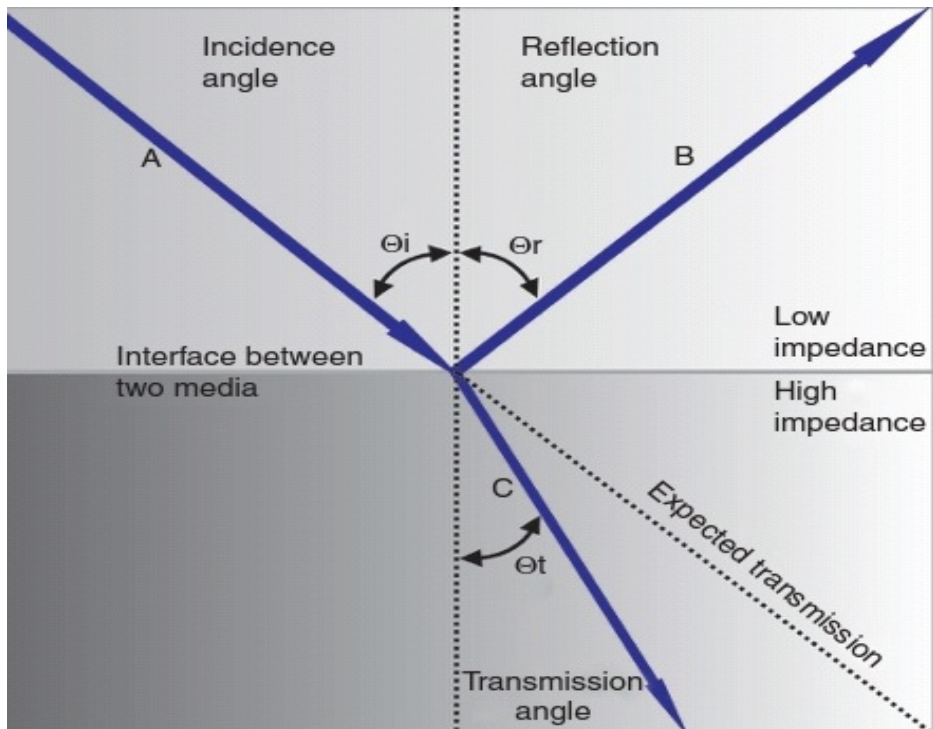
Interaction of ultrasound wave through a medium
